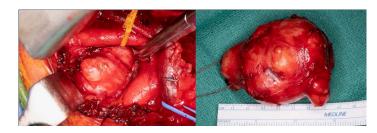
Successful R0 transthoracic resection of the mediastinal mass via trapdoor sterno-thoracotomy, demonstrating a well-circumscribed mass between the innominate and left common carotid arteries. Final size was $7.5 \times 5.8 \times 5.3$ cm. Samples sent for pathology revealed encapsulated nodular tumor with no evidence of spread to regional lymph nodes (0/10 left thymic and left internal mammary nodes), consistent with diagnosis of benign mediastinal lymphadenopathy.
